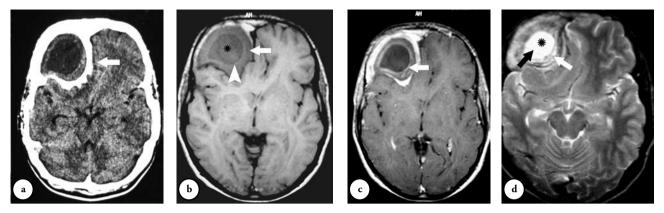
Patient images showing a) axial CT scan without intravenous contrast shows a diploic expansile hypodense lesion in the right frontal bone. b)
